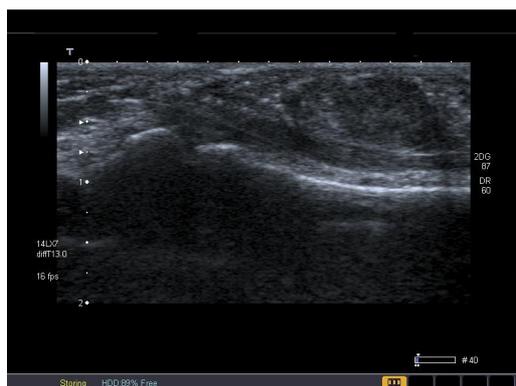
47-year-old woman with soft tissue swelling and mild pain in third finger flexor aspect. A homogeneous, hypoechoic, well-delineated solid mass adjacent to the tendons was seen in ultrasound. The pathological result was giant cell tumor of the tendon sheath.
